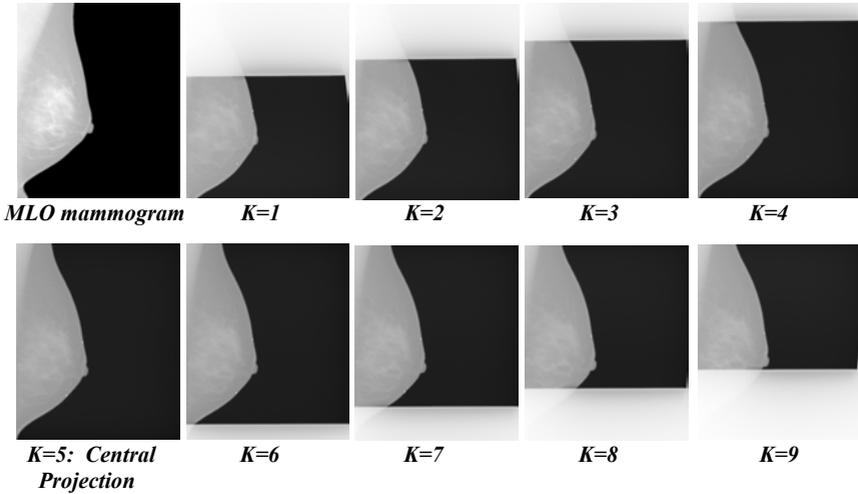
The clinical images used for the registration of an MLO mammogram (upper left) and the tomosynthesis source projection images ($K=1, \dots, 9$) of the same breast. The images were acquired the same day by the same technologist, with nearly the same breast positioning. The mammogram and the central projection ($K=5$) were acquired with the same geometry, but with different dose. The non-central projections ($K \neq 5$) were acquired with different x-ray focus locations.
